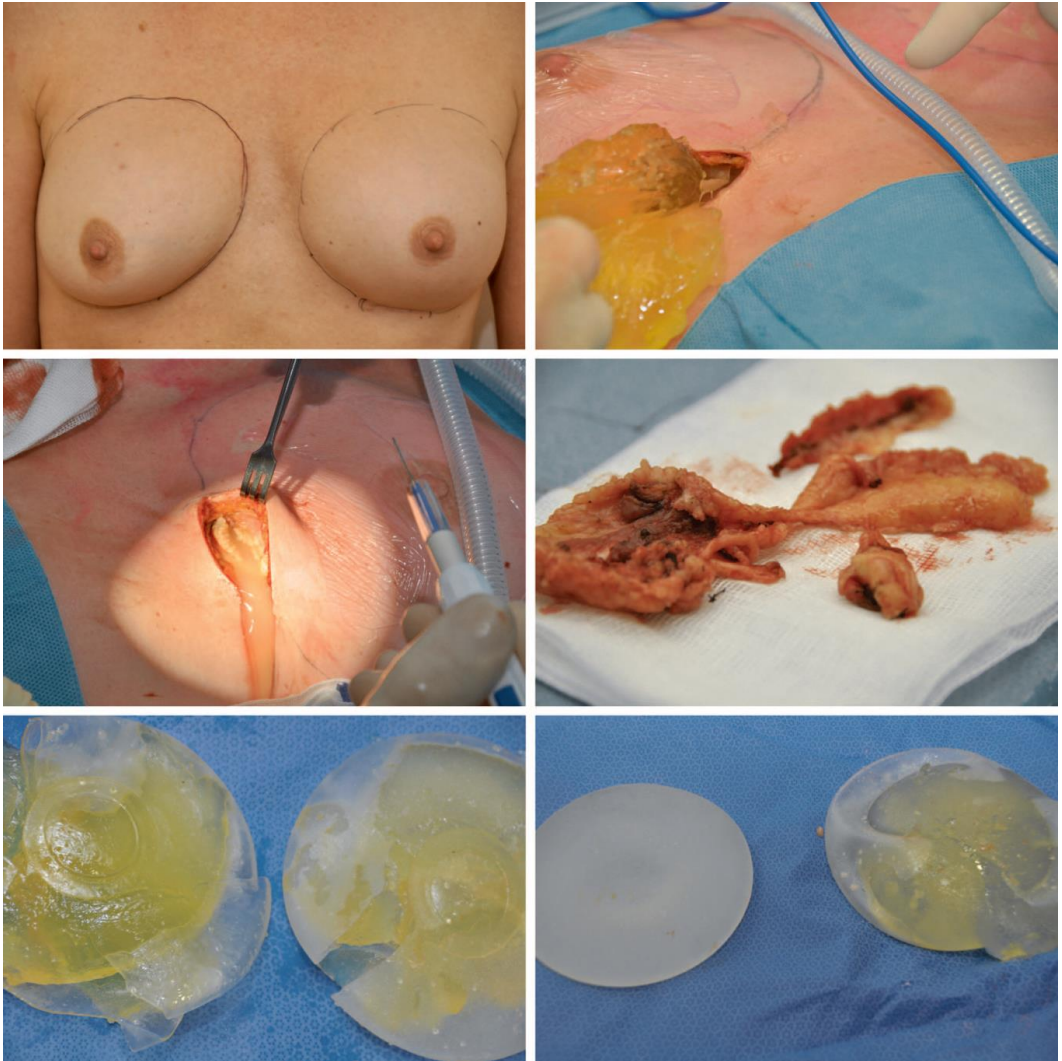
(Above, left) Patient with 305-ml Poly Implant Prothèse implants with subglandular implantation in the year 2001 reported no preexisting complaints, and at physical examination a change in form and asymmetry was found. (Above, right) Magnetic resonance imaging screening showed both implants to be ruptured, and explantation was performed. (Center, left) The milky liquid “bleed” seen in this patient was at times also seen in patients with intact implants. (Center, right) Capsulectomy was performed on both sides. (Below, left) Both Poly Implant Prothèse implants were found to be ruptured at explantation. (Below, right) A patient with Poly Implant Prothèse implants, of which one is intact and one is ruptured at explantation. One can notice the difference in structure, consistency, and even color of the silicone gel once the shell is torn and the silicone gel is exposed to the patient’s own tissue
